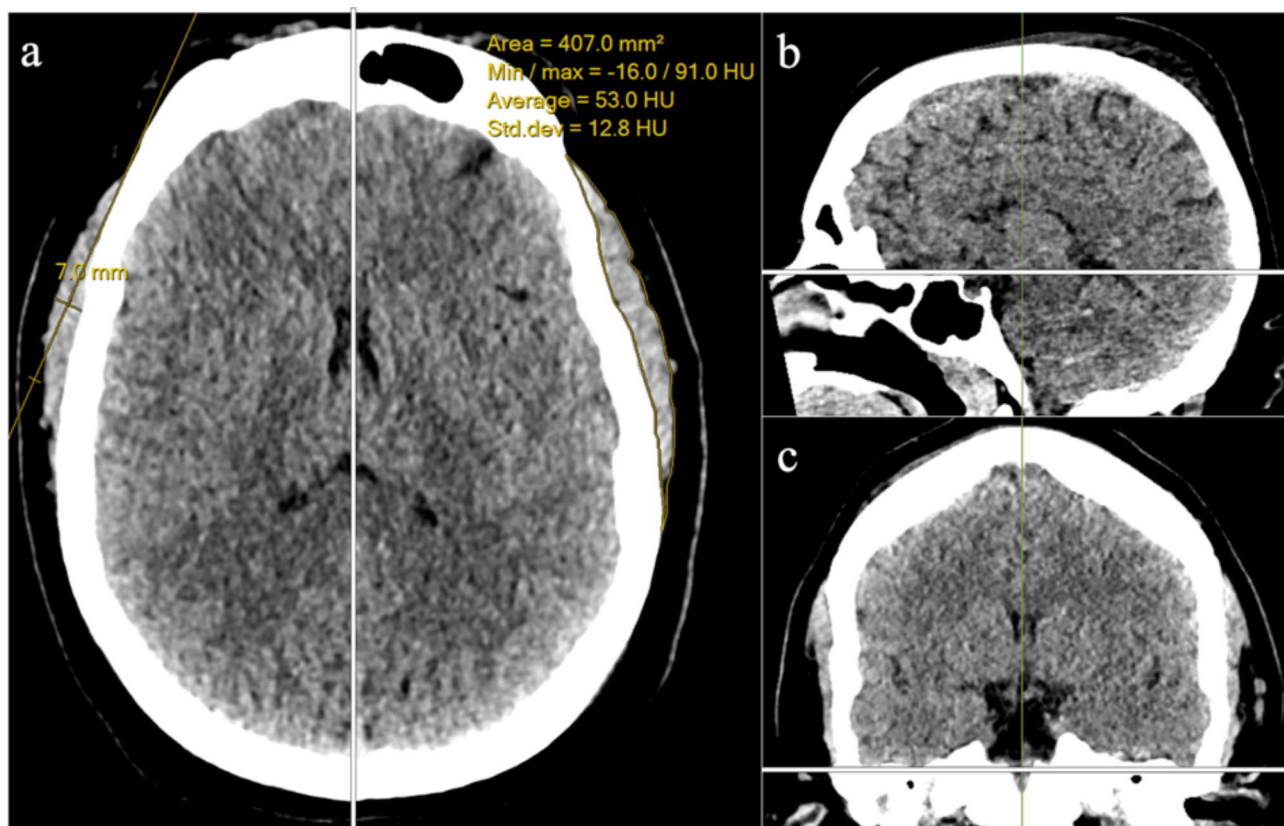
A head CT scan demonstrating temporal muscle thickness (TMT) measured on the patient's right (shorter yellow line; 7.0 mm), and temporal muscle area (TMA) and radiodensity on the patient's left (yellow line; 407.0 mm², 53.0 HU) (a). The measurement slice was aligned parallel to the anterior skull base semi-axially (b; white line), parallel to the falx cerebri sagittally (a; white line), and tangential to the floor of the middle cranial fossae coronally (c; white line). The measurements were performed on the first semi-axial slice superior to the soft tissues of the orbit (a).
